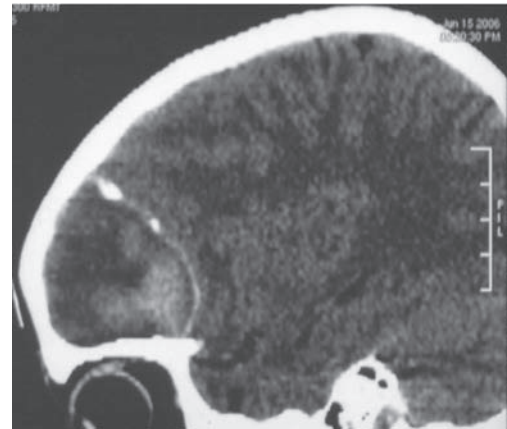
Noncontrast CT scan (sagittal reconstruction) of the same patient showing hyperdense calcified walls
